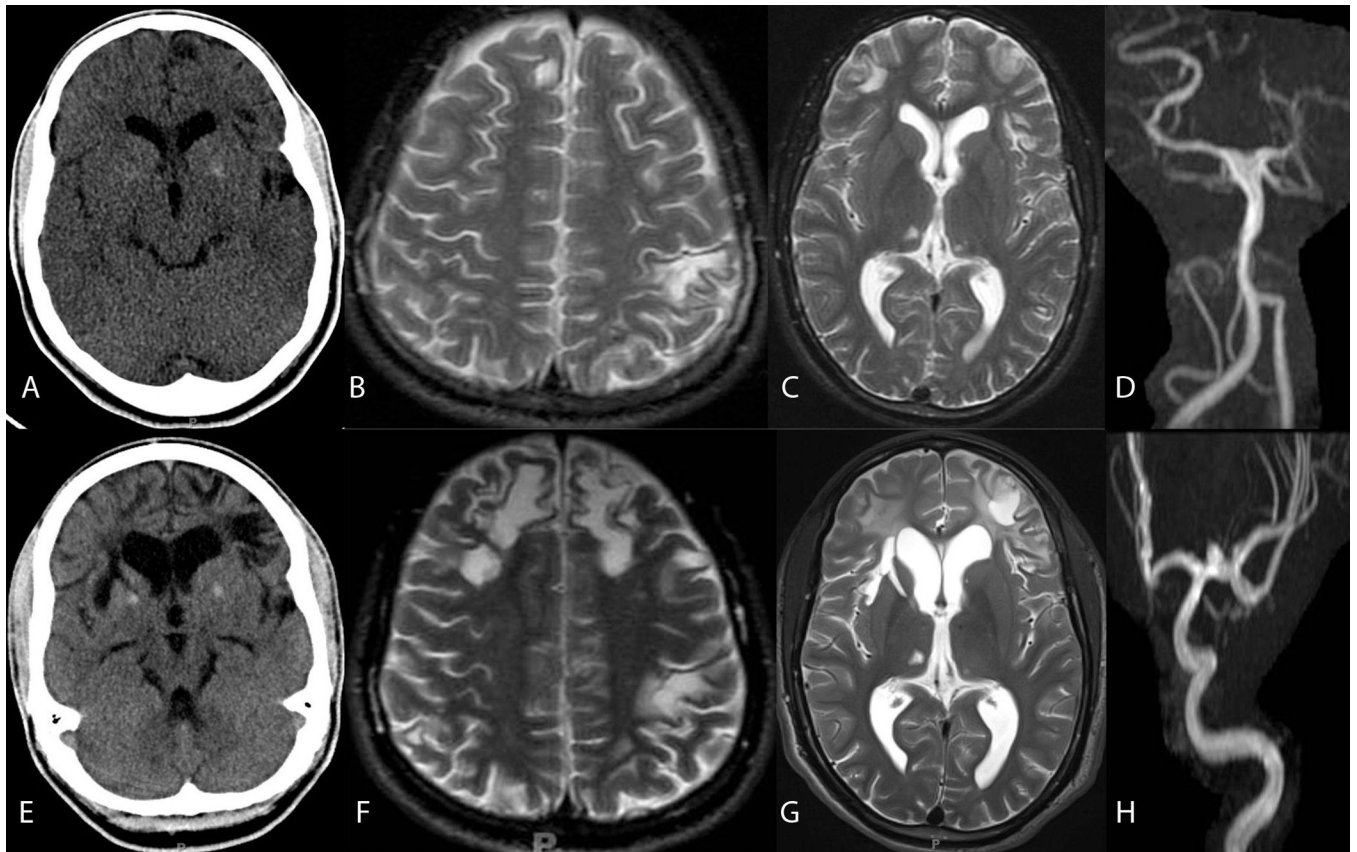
Patient #4. The first row shows representative CT and MRI findings at the first presentation. The second row shows same patient's CT and MR images at similar levels after 6 years. Note the increase in basal ganglia calcifications, increased number of focal infarcts and increase in cerebral volume loss.
